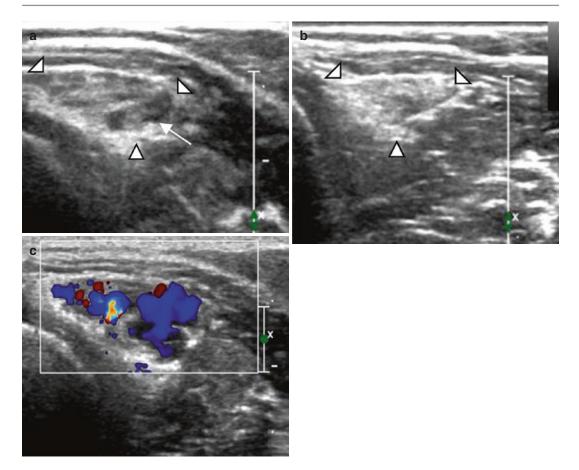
Five-year-old girl with intramuscular venous malformation. (a) Ultrasound image. (b) Ultrasound image after local compression. (c) Color Doppler image. (a) Ultrasound image shows a heterogeneous lesion
